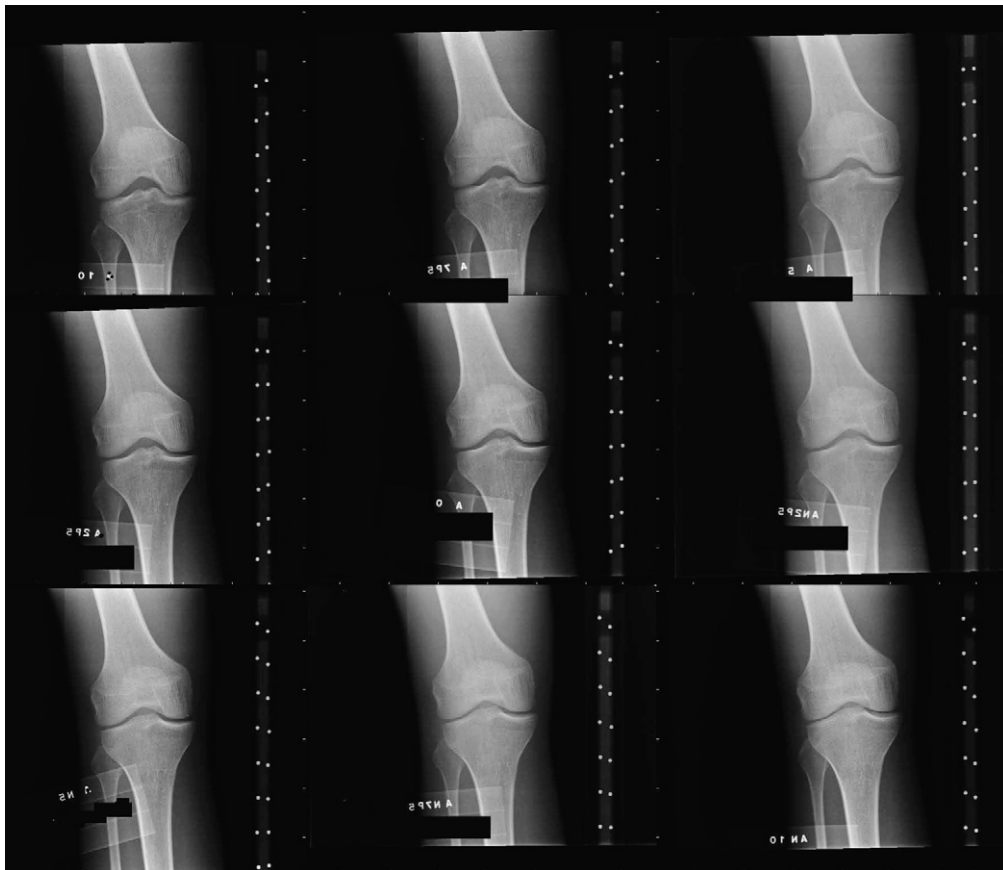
Examples of radiographs for obtaining an optimal tibiofemoral plateau alignment (acquired with X-ray beam angulation ranging from 10° caudal to 10° cranial in 2.5° increments, upper left to lower right). Note the optimum at 2.5° cranial (middle right image) with an IMD ~ 1 mm at the center of the medial compartment.
